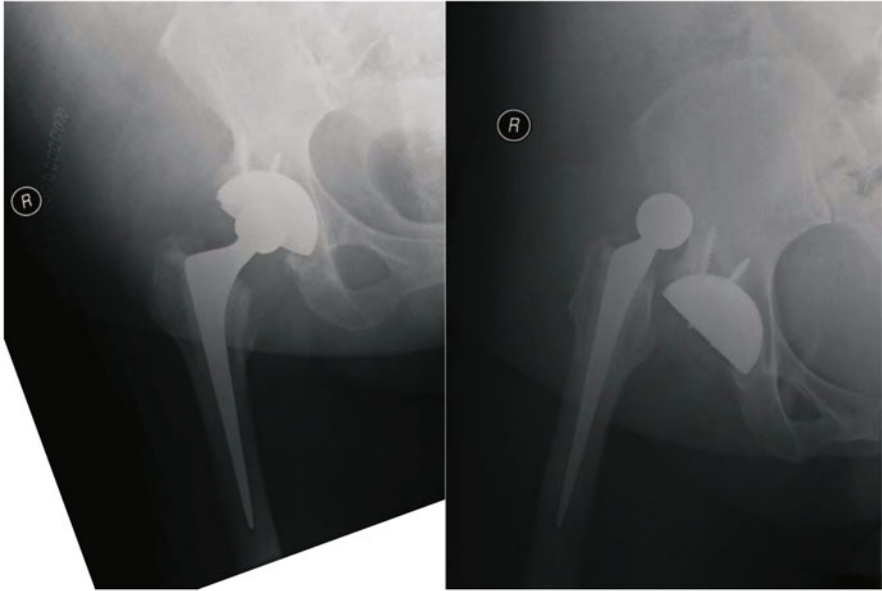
Radiographs of a pseudotumour case, revised to a hybrid (THA) with a 32 mm femoral head that dislocated within weeks post-op
